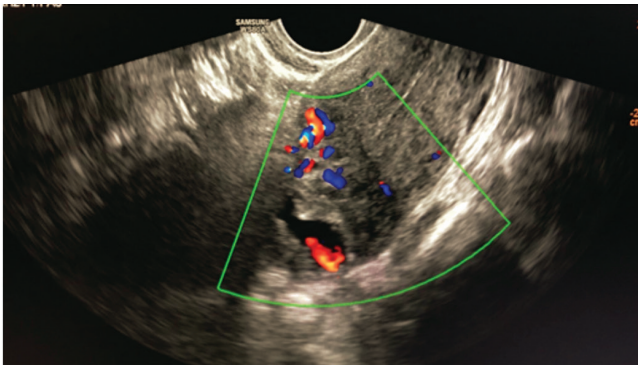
Initial transvaginal ultrasound showing moderate color doppler flow in the left complex adnexal mass
